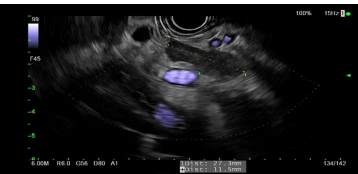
Endoscopic ultrasound (EUS) showing a homogenous well-defined hypochoic lesion in the tail of the pancreas measuring 11 x 27 mm
